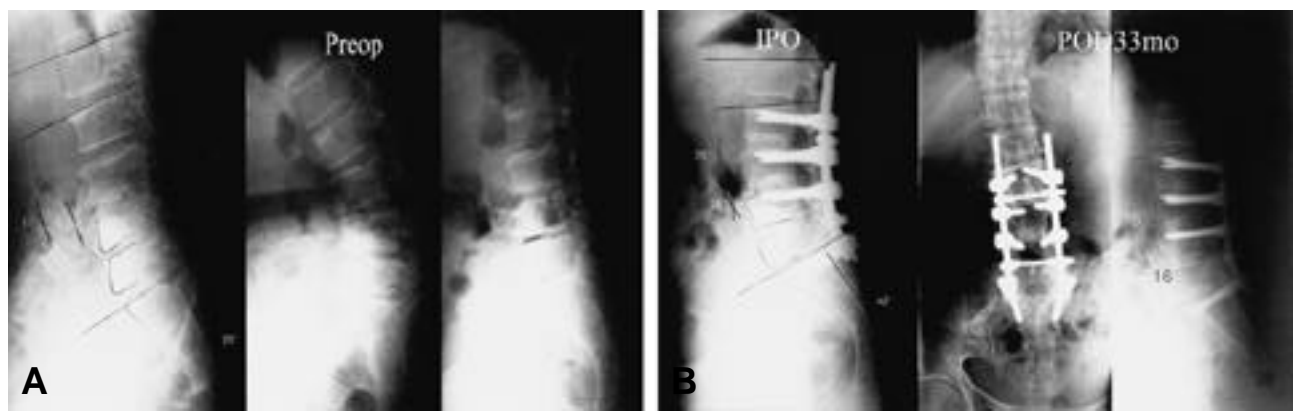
Preoperative lateral radiography of 64-year-old woman shows disc degeneration of L4-5 L5-S1, wedge vertebrae L4 L5, and segmental instability L3-4 L4-5 in flexion-extension view.
